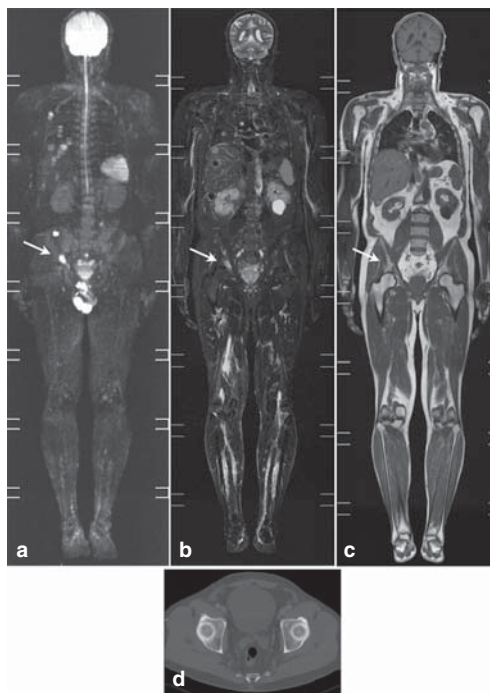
A 64-year-old man with malignant melanoma and multiple metastases. A bone lesion (arrow) measuring approximately 15 mm in longest diameter was detected on the right acetabulum on maximum intensity projection (MIP) image of DWI (a); coronal T2-STIR image (b) and coronal T1W image (c); The lesion was not detectable on CT (d).
